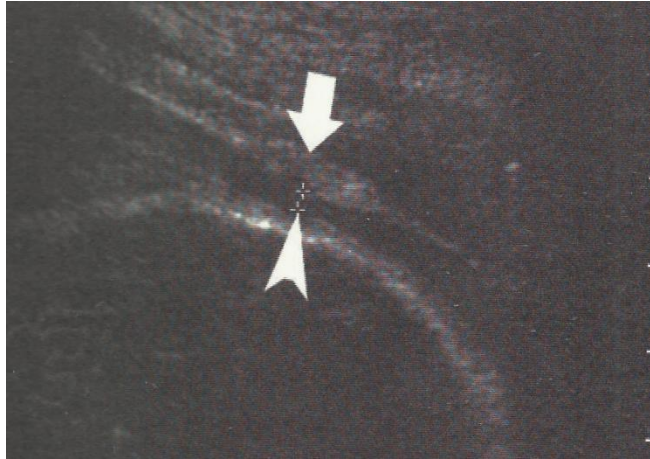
Longitudinal Sonogram showing an area of increased echogenicity in the outer layer (arrow) with myometrical thinning
